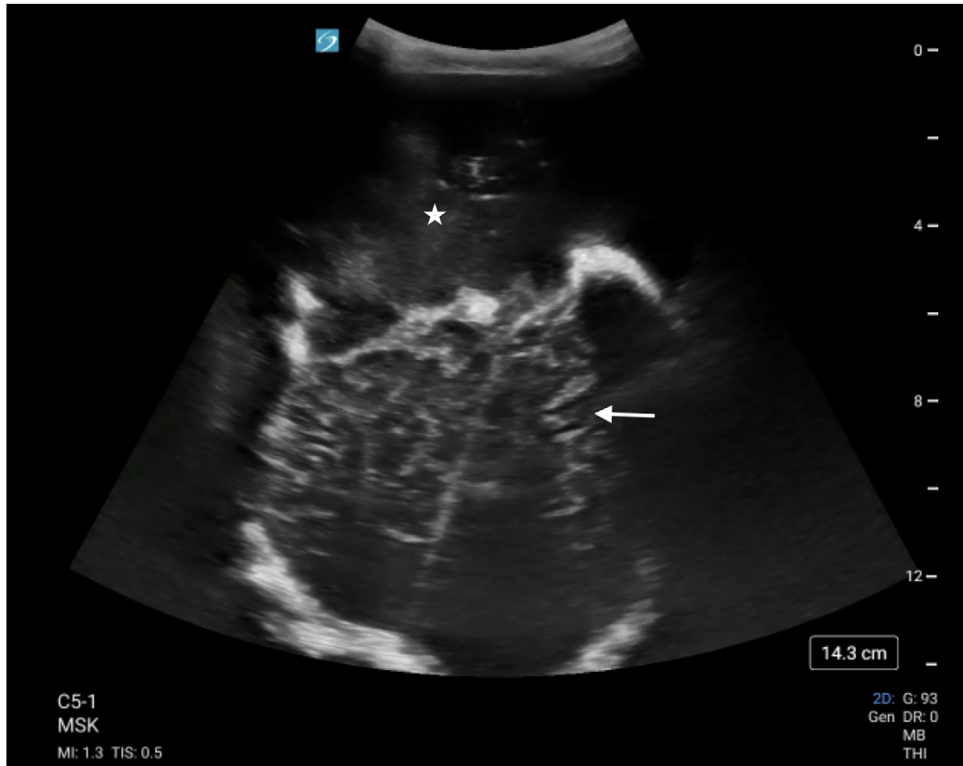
Ultrasound image of soft-tissue mass on scalp (*) and brain gyri (arrow).
